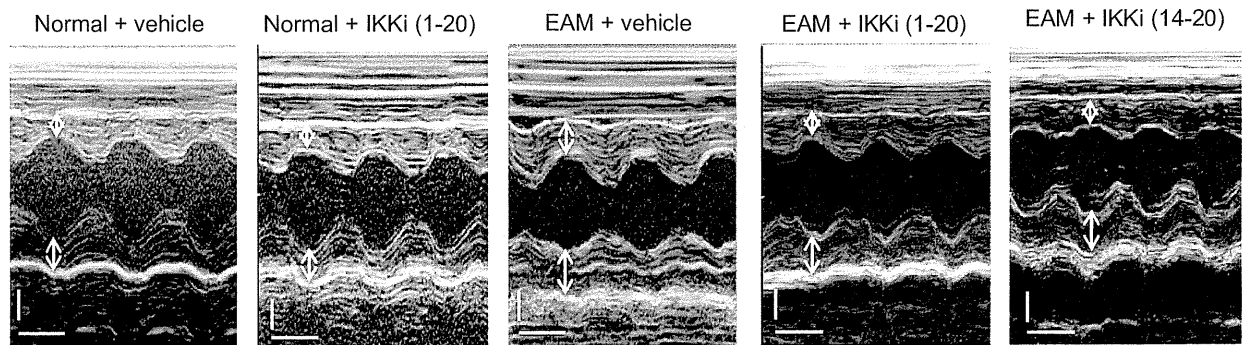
Representative M-mode echocardiograms on day 21. Arrows indicate anterior and posterior walls of left ventricle. Scale bars: 2 millimeter (vertical) and 0.1 s (horizontal).
